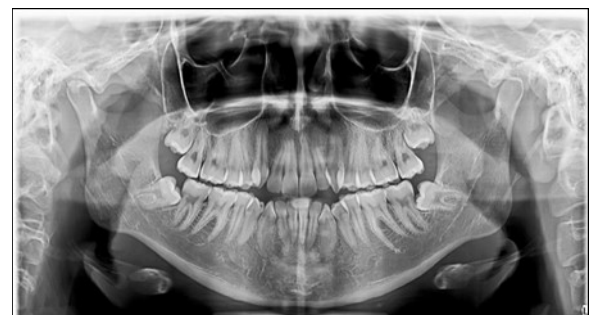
Pretreatment panoramic X-ray
